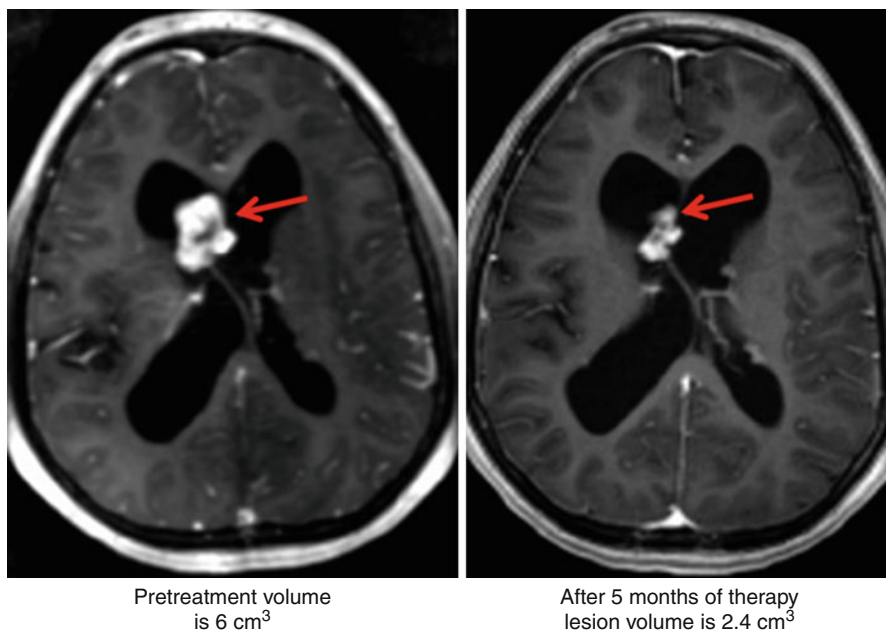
Case report: Reduction in size of SEGA after 5 months of rapamycin therapy. (*Left*) Pretreatment: lesion volume is 6 cm³. (*Right*) After treatment: lesion volume is 2.4 cm³. Axial T1 contrast-enhanced MRI. *Red arrows* point to the SEGA lesion which has shrunk in the right side compared to the left (Reprinted with permission from Franz et al. [54])
